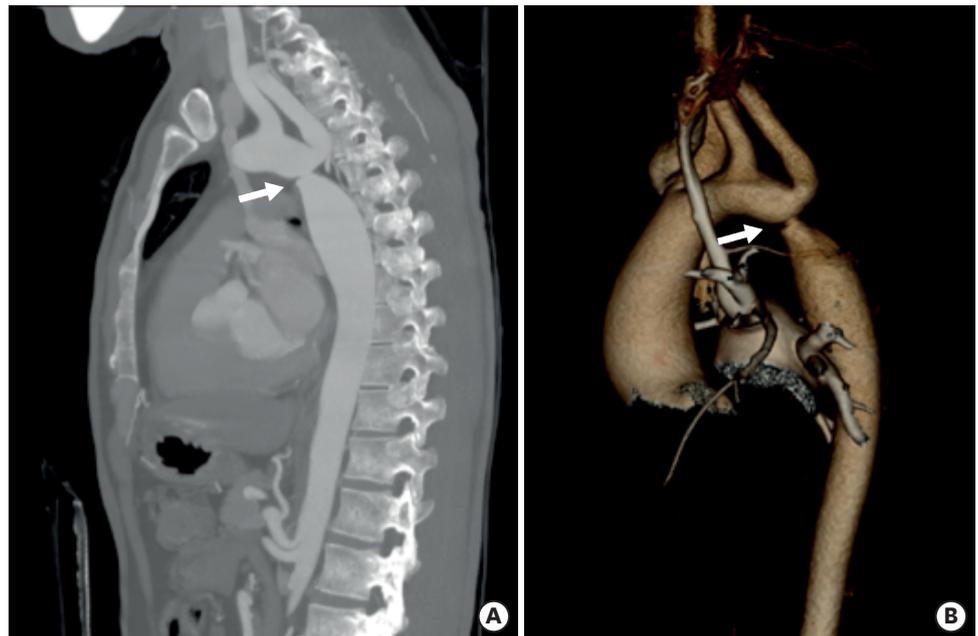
(A) Computed tomographic angiogram is revealing coarctation of the aorta just at the origin of the left subclavian artery (arrow). (B) 3D volume rendered reconstruction of the same patient revealing the coarctation (arrow), note the incidental finding of persistent left superior vena cava to left atrium.
